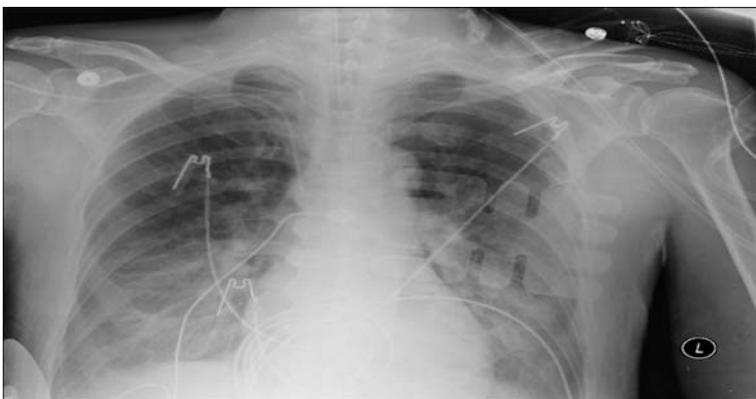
Chest radiograph. Pulmonary vascular congestion is present in both lungs
